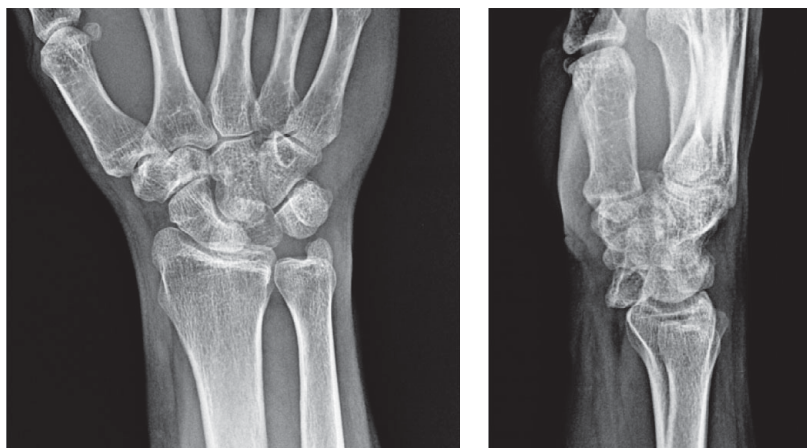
(a) Anteroposterior (AP) and (b) lateral radiographs right wrist
